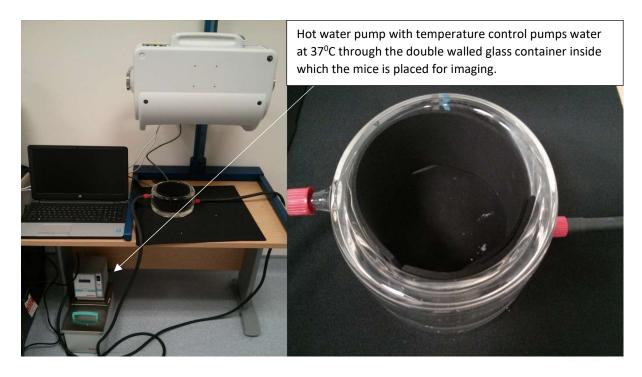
2 Jacketed glass jar and laser Doppler setup
